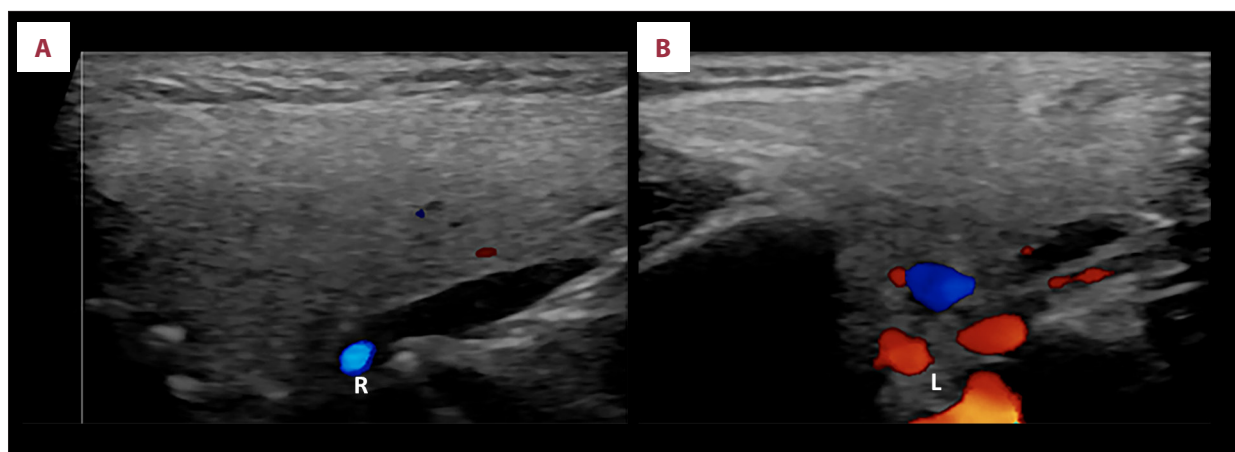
Color Doppler ultrasonographic images of the right (A) and left (B) parotid glands demonstrate homogeneous parenchymal echotexture without abnormal vascularity.
